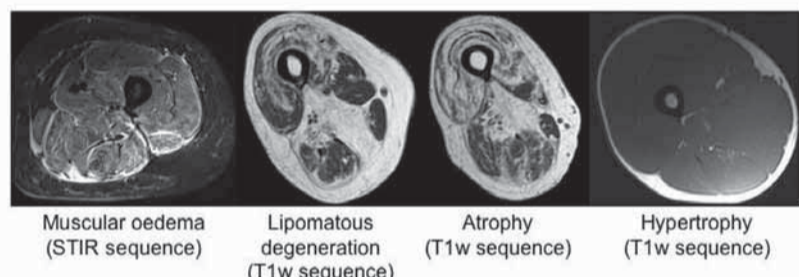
Typical pathologic changes of muscle tissue shown in standard proton (¹H)-magnetic resonance imaging (MRI)
